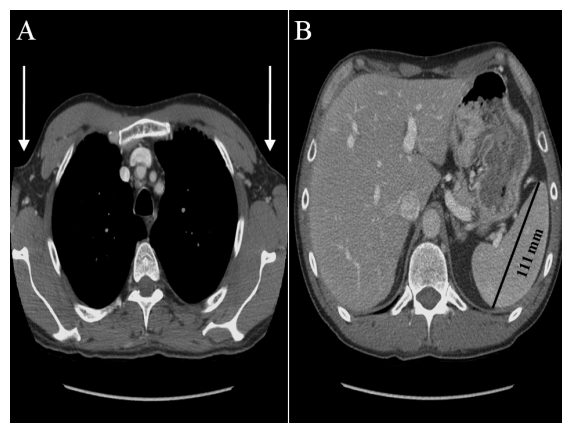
Computed tomographic (CT) scan at 3-year follow up showing normal findings in the chest (A) and further resolution of splenomegaly (B).
